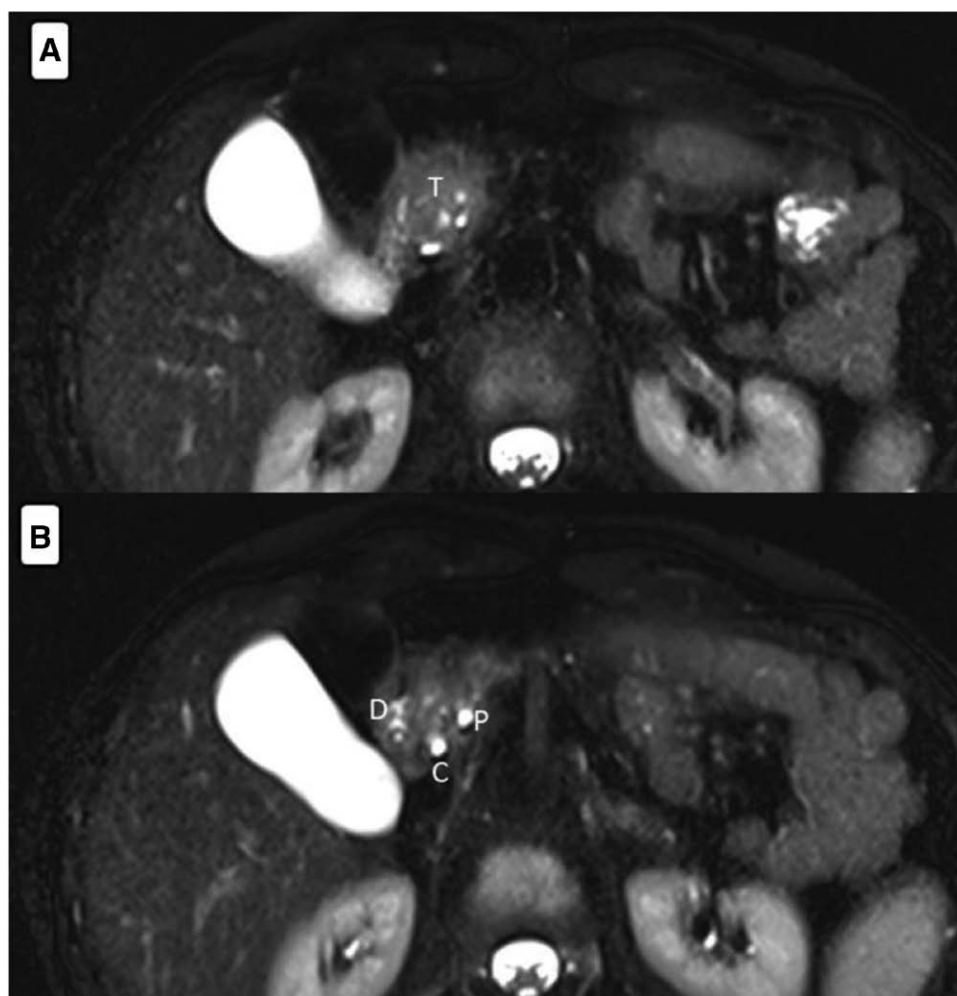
T2-weighted fat-saturated magnetic resonance imaging (MRI) of a 54-yr-old male patient. (A) A 3cm tumor (T) located in the head of the pancreas, with no evidence of vascular invasion. (B) Adjacent tissues to the tumor; P: Dilated pancreatic duct, C: Common bile duct (CBD), D: Duodenum (Siemens Magnetom Avanto 1.5T MRI scanner, 1.5 Tesla field strength).
